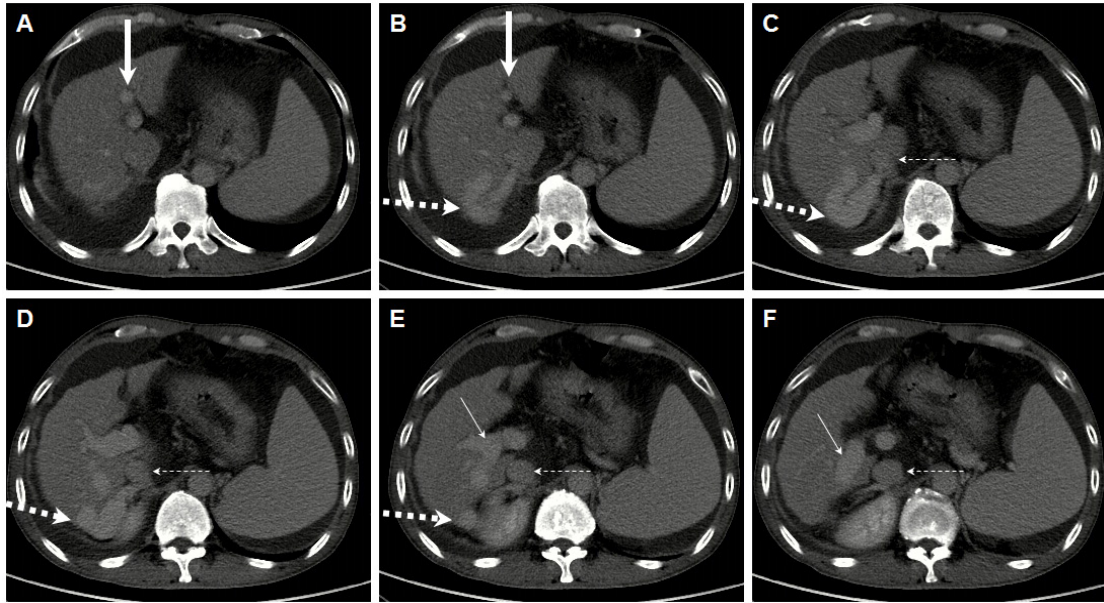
Abdominal axial contrast-enhanced computed tomography scans in the venous phase showing a spontaneous intrahepatic portosystemic shunt. Panels A-F are CT scans from top to bottom. The right portal branch (*fine solid arrow*) communicates with the inferior vena cava (*fine dashed arrow*) through a large portosystemic collateral vessel (*thick dashed arrow*). Notes: A thick solid arrow represents the left portal vein branch, a fine solid arrow represents the right portal vein branch, a thick dashed arrow represents the collateral vessel between the right portal vein branch and inferior vena cava, and a fine dashed arrow represents the inferior vena cava.
